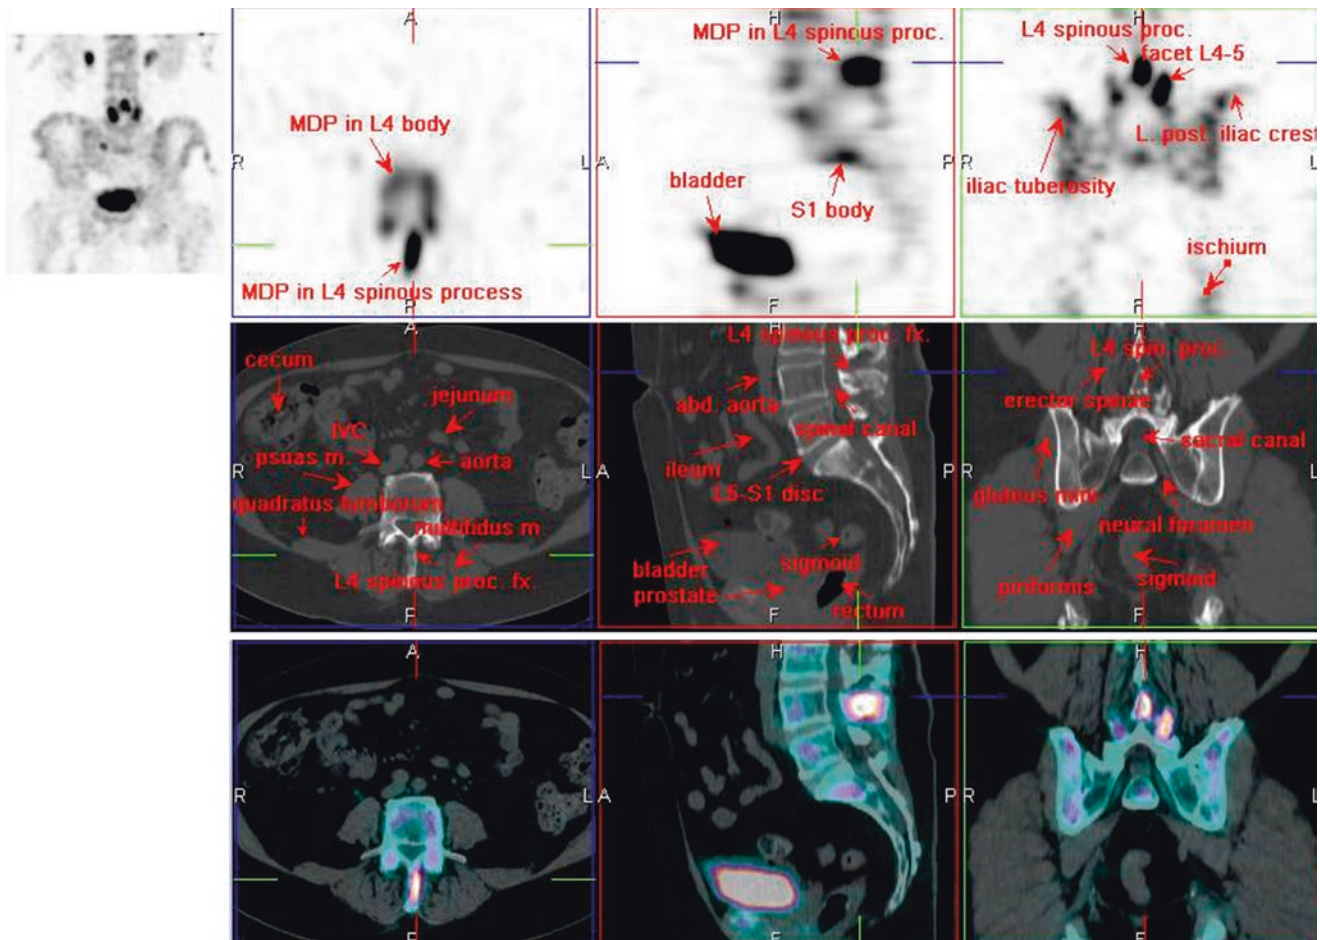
^{99m}Tc-MDP SPECT/CT
